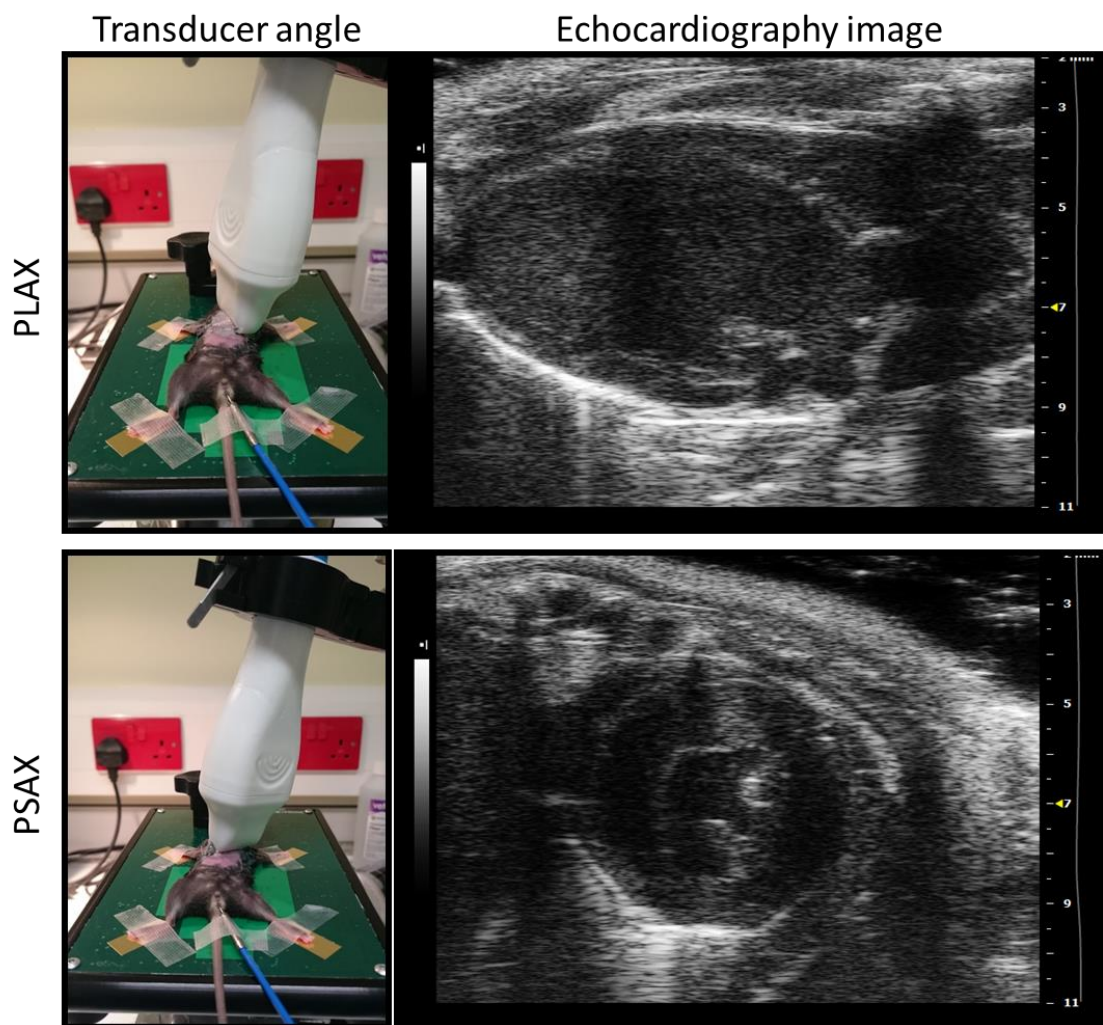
Obtaining PLAX and PSAX echocardiography images.
